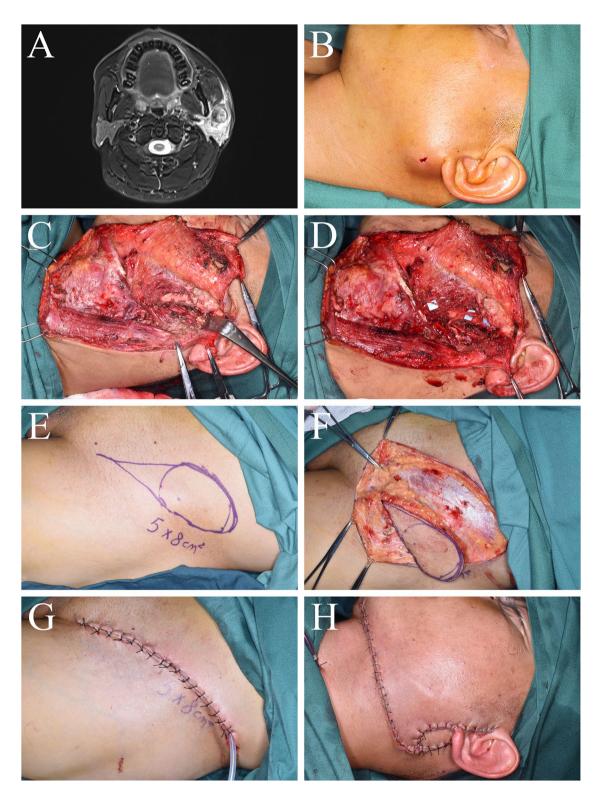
The surgical procedure of Patient No. 10, in which a SCIP flap was used to restore the radical parotidectomy defects. (A) T2-weighted MRI imaging. (B) Preoperative recipient site. (C) Recipient site after tumor resection. (D) Facial nerve reanimation. (E) SCIP flap design. (F) Harvesting of SCIP flap. (G) Closure of donor site show well incision concealment. (H) Closure of recipient site show well volume and color compatibility
